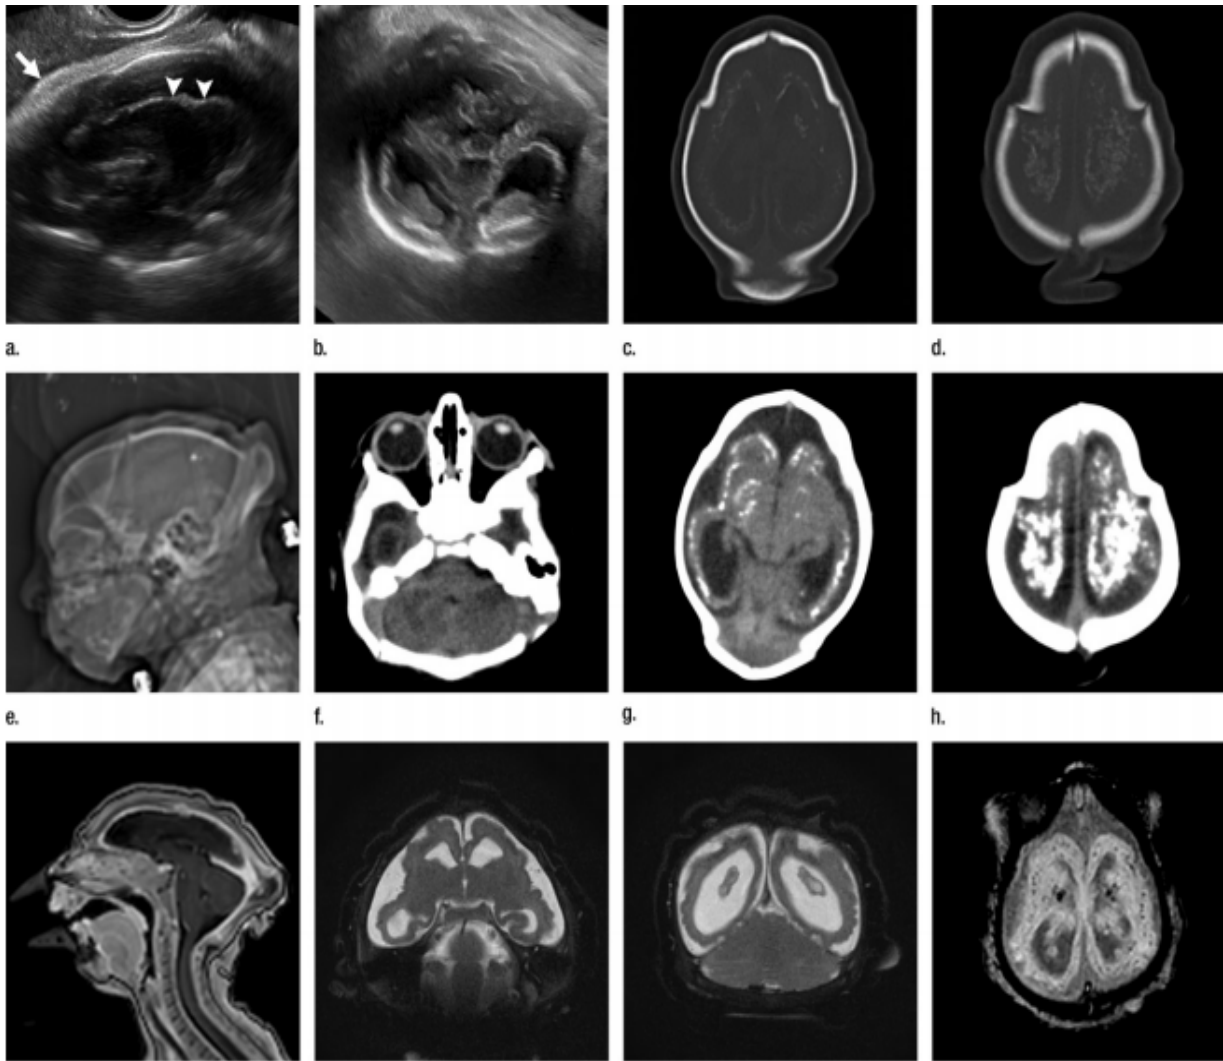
Images relating to a case of an 18-year-old woman with confirmed ZIKV infection. a, sagittal transvaginal and b, coronal transabdominal ultrasound images obtained with the head upside down show a small head circumference, moderate ventriculomegaly with dense intracranial calcifications and abnormal head shape with flattened appearance and thickened skin; c, d, axial bone window CT images; e, sagittal localizer CT image; f-h, axial CT images show microcephaly with cerebral atrophy, and, despite ventriculomegaly, the extra-axial CSF spaces still prominent. The dense calcifications are predominantly located in the subcortical white matter at the gray matter–white matter interface. There is markedly abnormal skull shape with some eversion of the bones at the suture sites (particularly fronto-parietal sites), with redundant skin folds (particularly in the parieto-occipital region). i, sagittal T1-weighted, j, k, coronal T2-weighted and l, axial susceptibility-weighted MR images obtained at 1 month of age show an undersegmented midbrain, severe microcephaly, open sylvian fissures, and polymicrogyria. The dense calcifications are evident on the susceptibility-weighted image. [adapted from 98]
